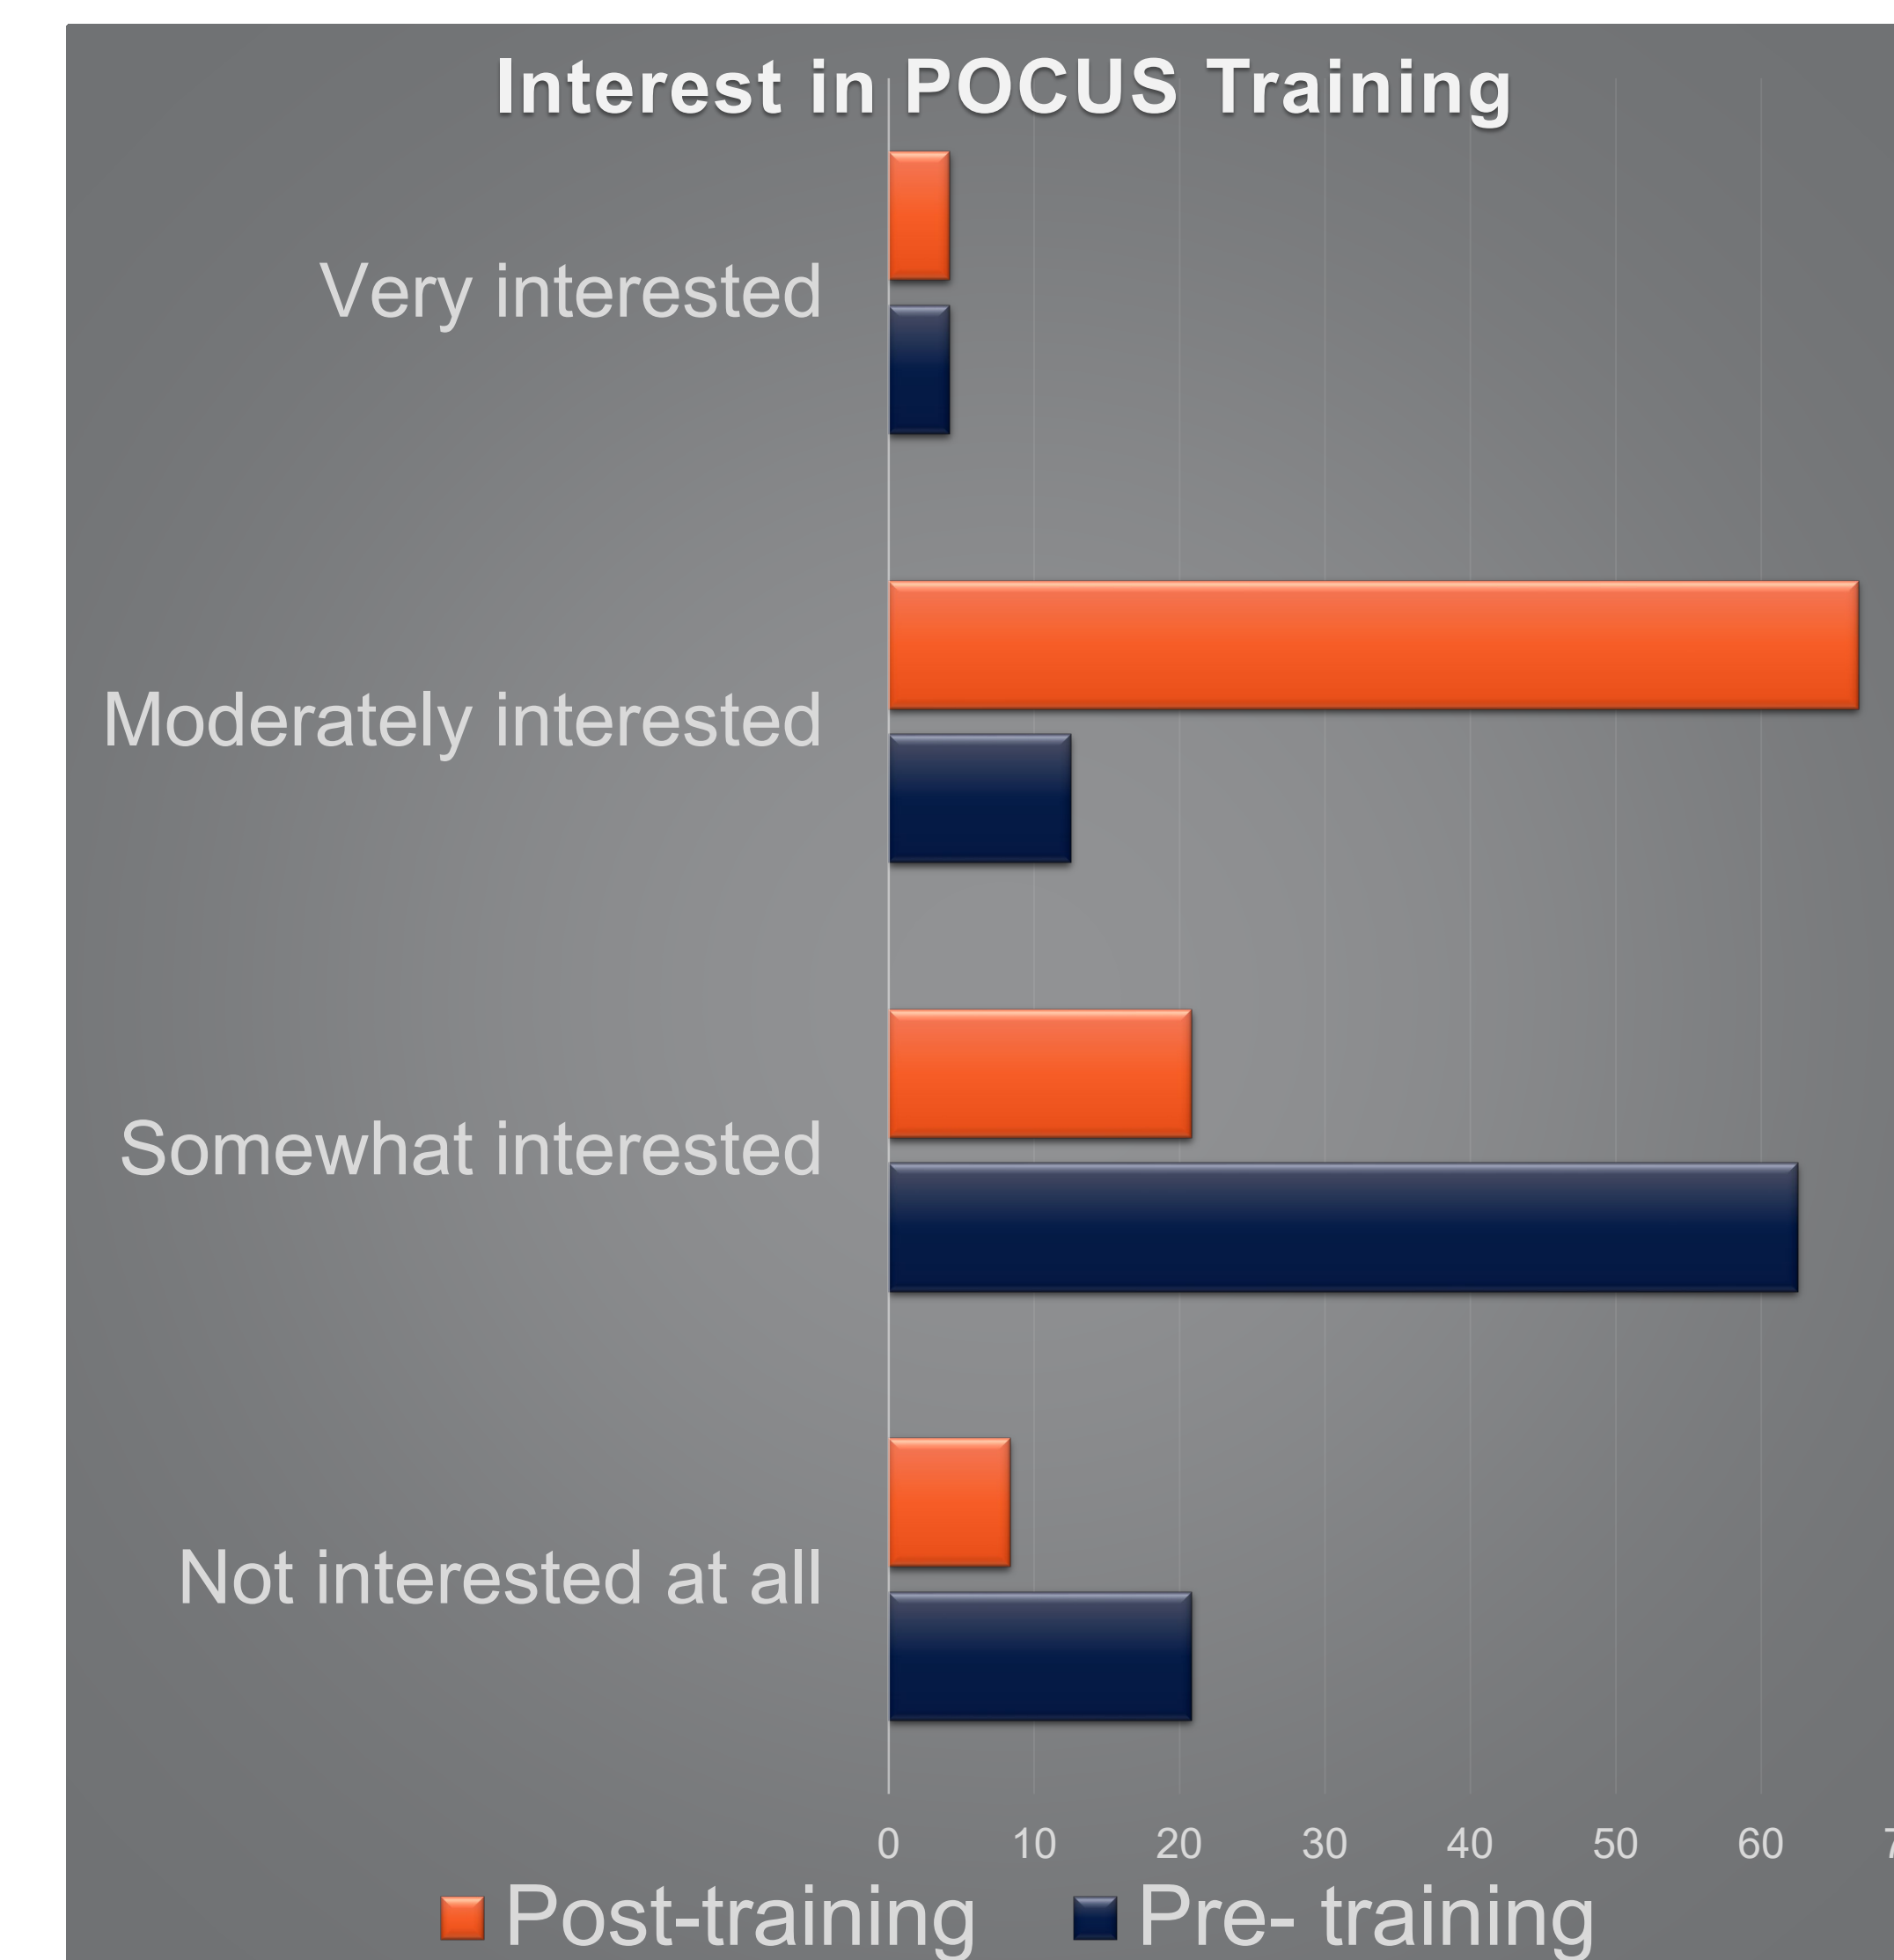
How interested are you in being trained with Point-of-care Ultrasound? (Pre and post training)
